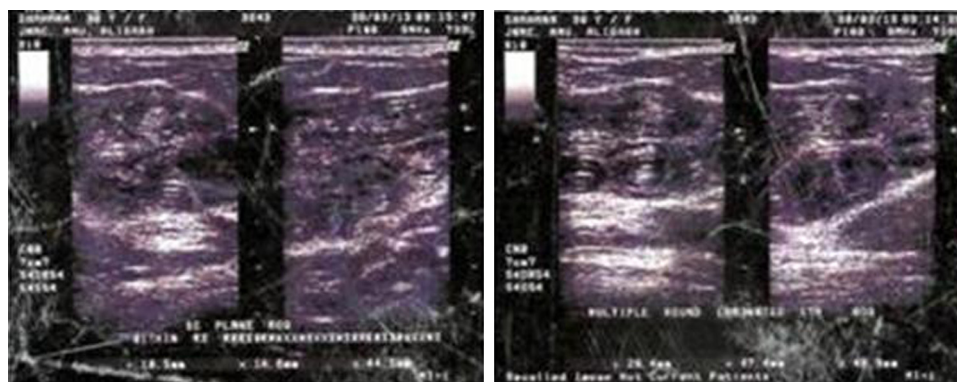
Breast ultrasound showing a large complex cyst containing multiple laminated structures diagnostic of a detached hydatid endocyst.
